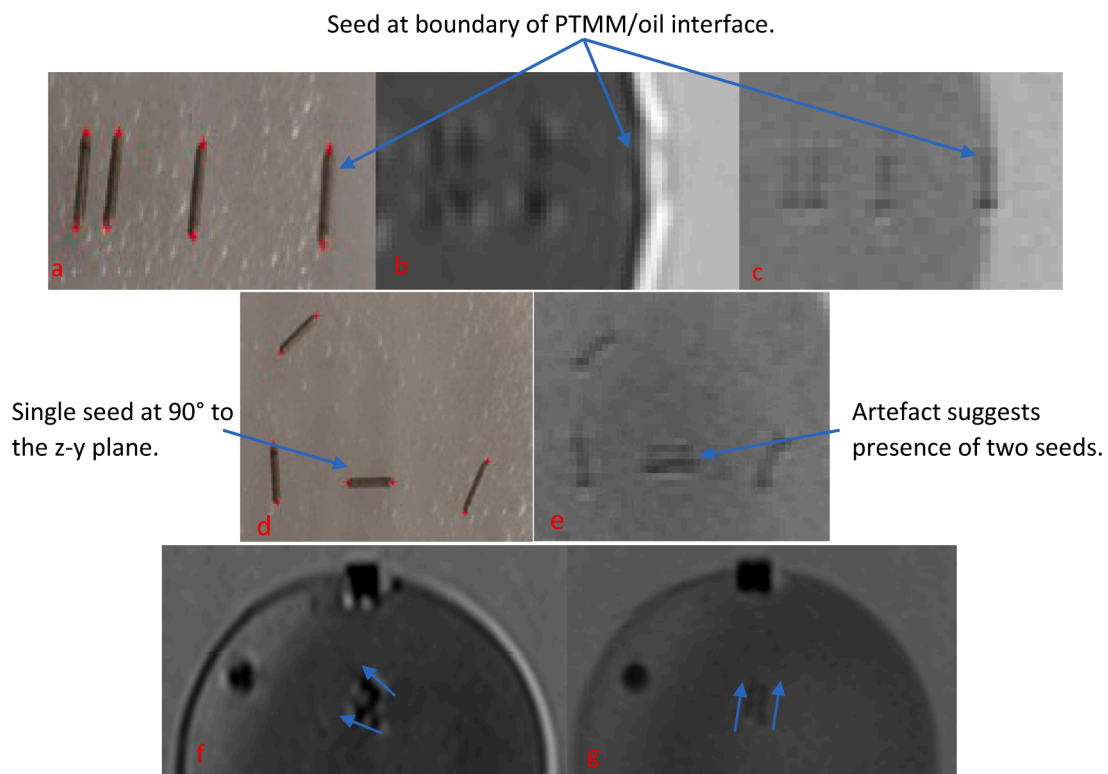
A seed at the boundary of the PTMM/oil in the photo (a) very difficult to see in S4 (b) clearer in S2 (c). A seed at 90° could be mistaken in the MR images for two seeds, photo (d), S2 (e). Uncertainty in seed direction in (f) without metal artefact correction, compared to (g) with metal artefact correction.
